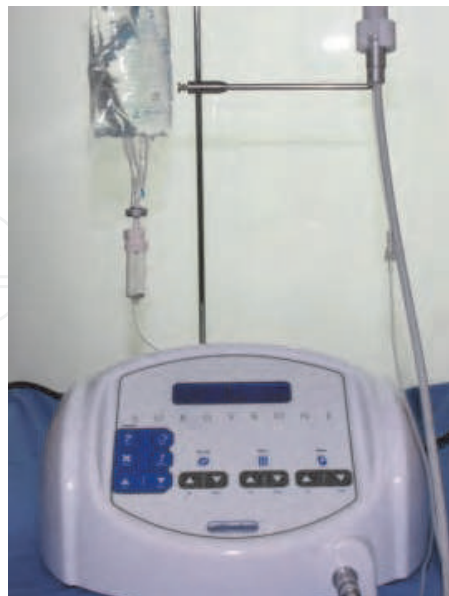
Ultrasonic piezoelectrci device (Surgybone®, Silfradent srl, Sofia, Italy). This decice works in hard tissue, not in the soft tissue. Therefore membrane perforation is rare when breaking sinus floor.
